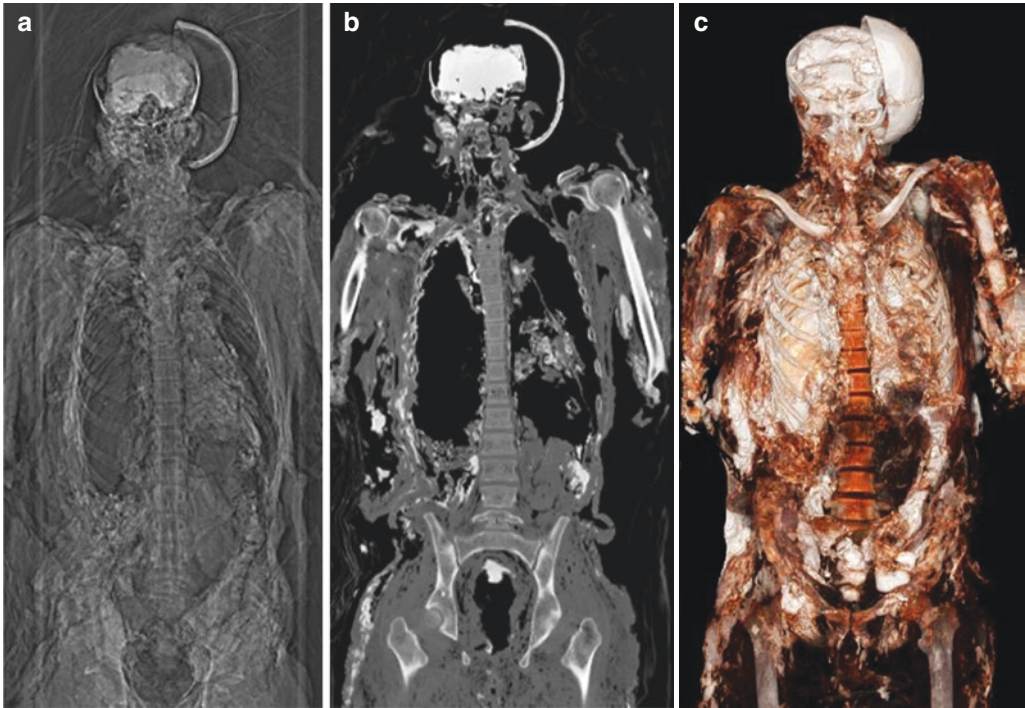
Postmortem CT of a drowned and saponified man. The scanogram or scout (a) precede CT scan. Post-processing can be very useful to integrate traditional
